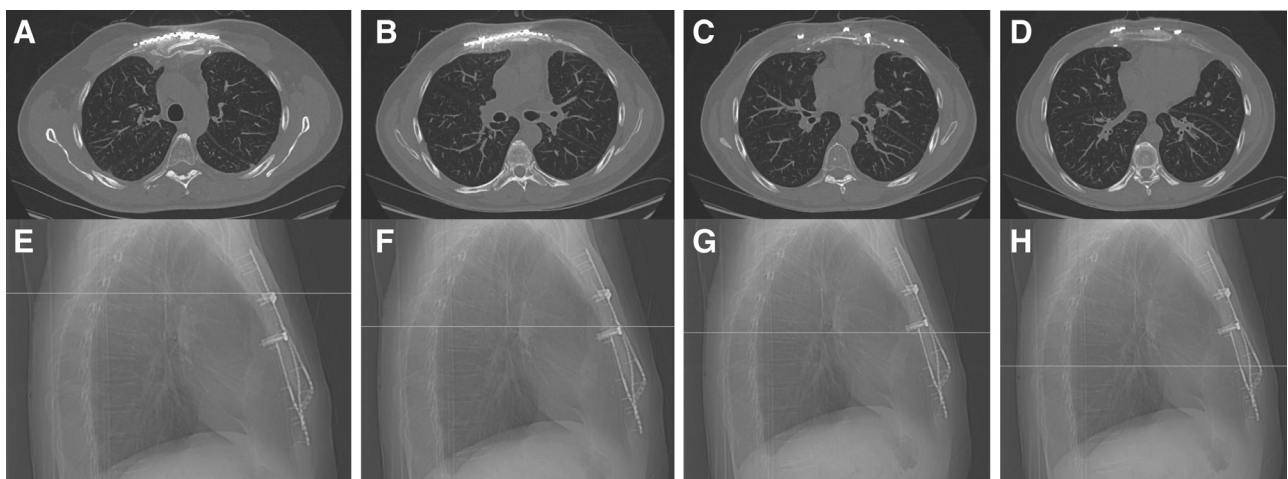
CT scans showing no evidence of recurrence. Axial views are paired with lateral views to show the progression of images from superior (A and E) to inferior (D and H) within the affected area.
